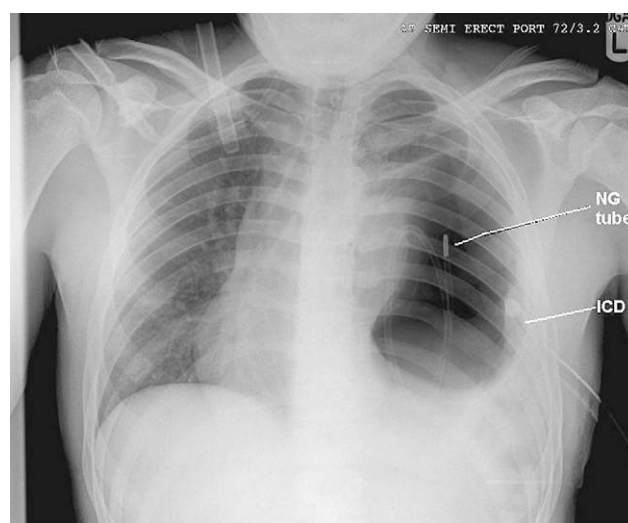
Chest radiograph after insertion of the nasogastric tube (NG tube) confirming that the stomach is within the left pleural space. (ICD: intercostal chest drain).
